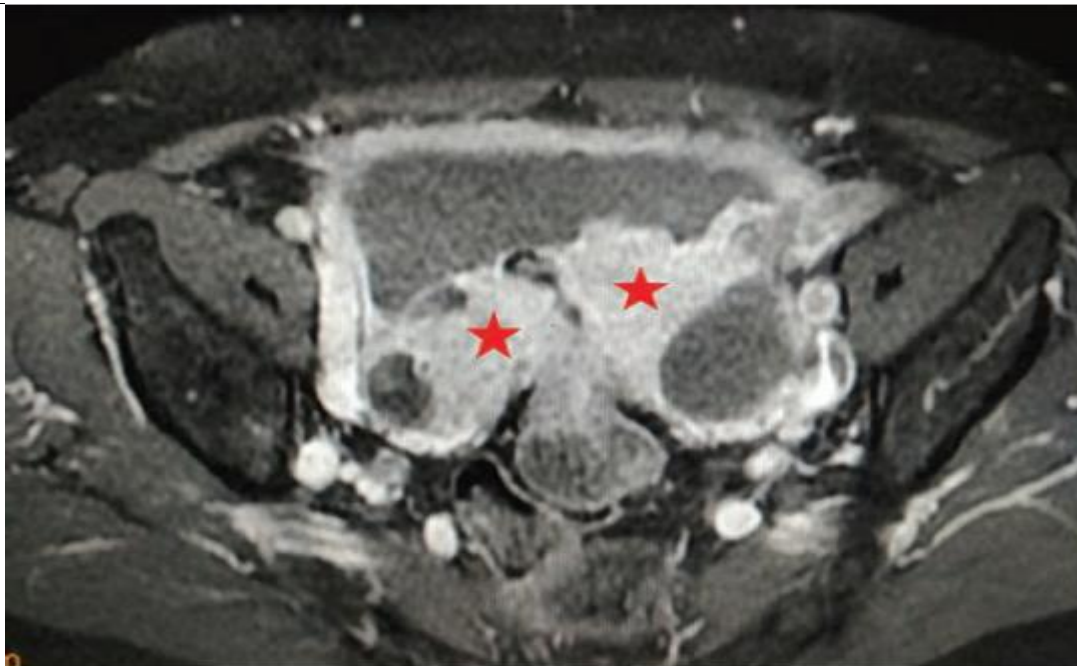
Axial T1 + contrast MRI demonstrating bilateral lobulated solid cystic lesions (stars) in bilateral adnexal regions. The solid component shows heterogeneous enhancement on post contrast images. Bilateral ovaries are not visualized separately, features are of concern for malignant ovarian etiology. MRI, magnetic resonance imaging.
